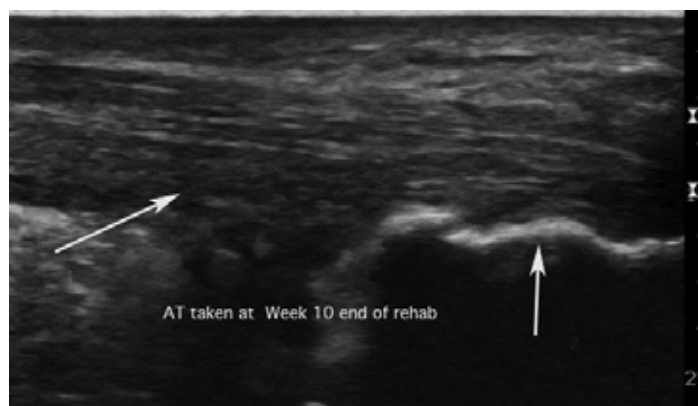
Sonogram after 10 weeks of physical therapy.
